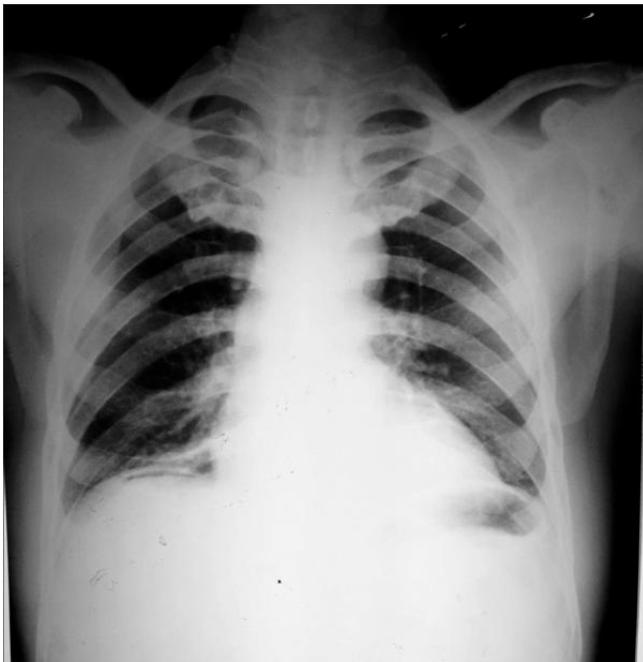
Chest x-ray PA view showing gas under right diaphragm.
